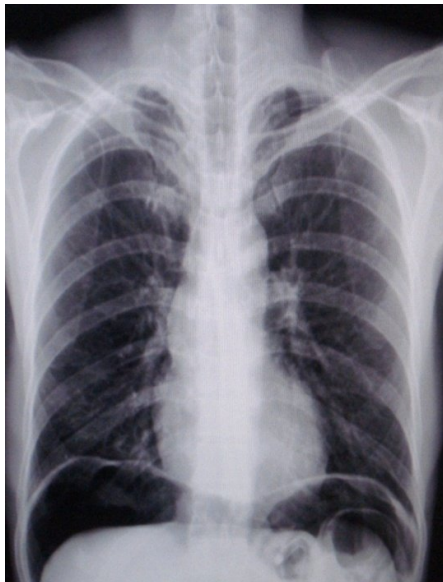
Air under diaphragm-x-ray chest²
